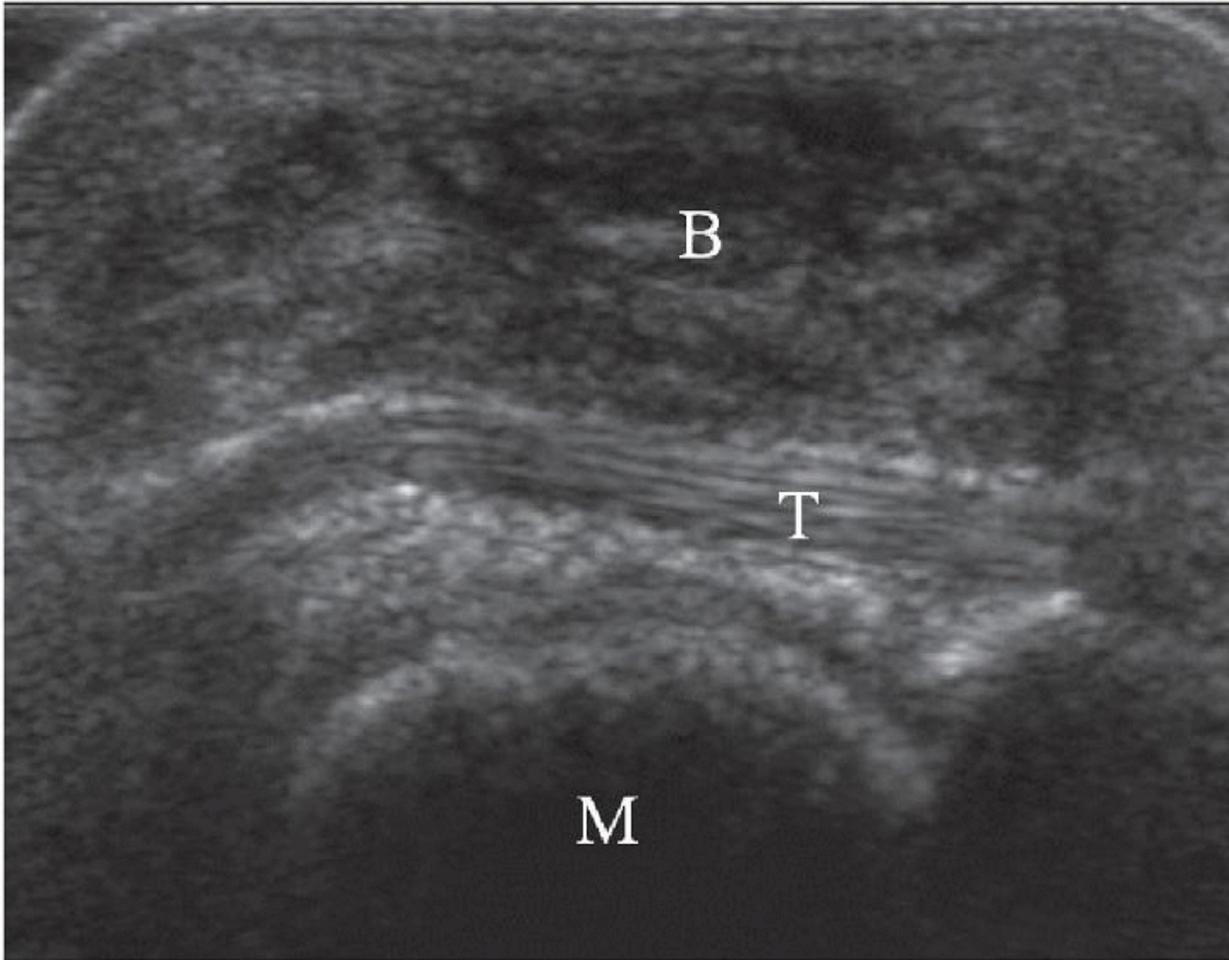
Rheumatoid bursitis superficial to first metatarsophalangeal joint. Longitudinal ultrasound scan shows enlarged hypoechoic bursa (B) superficial to flexor hallucis longus tendon (T) and first metatarsal head (M).
